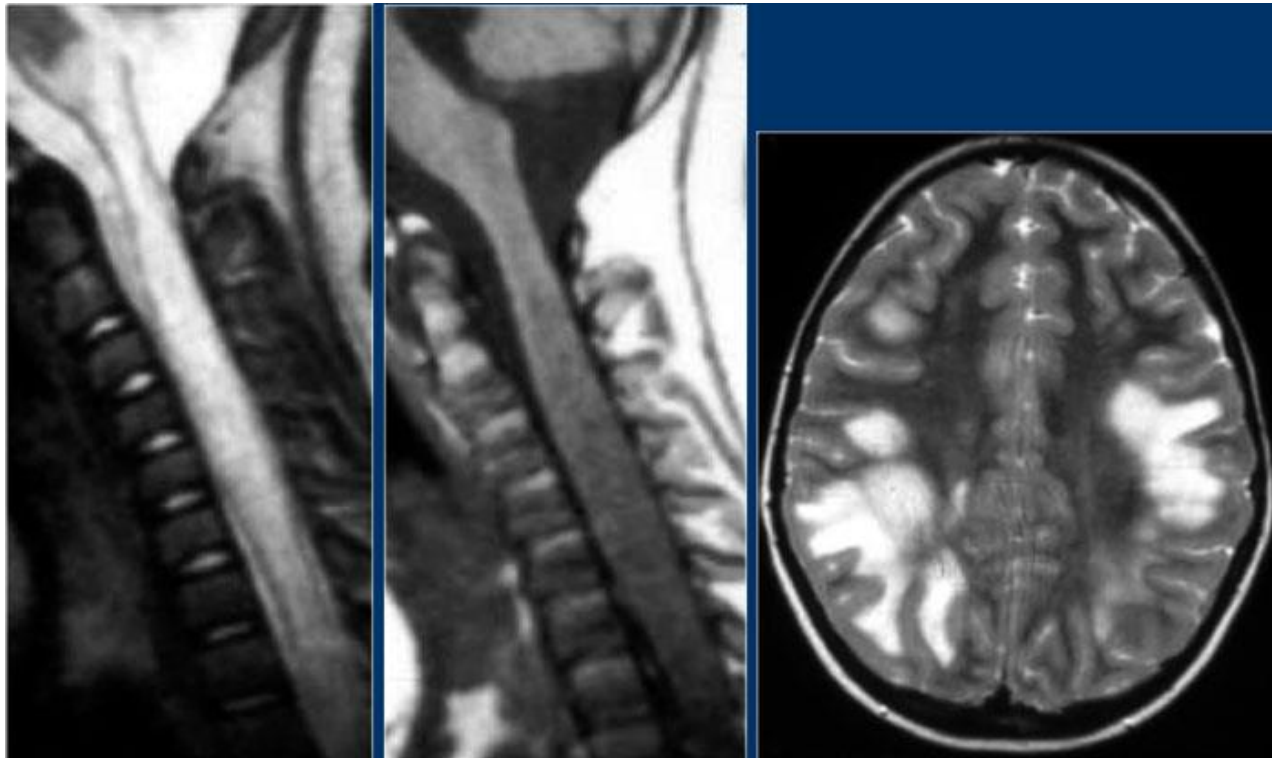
T2WI sagittal MRI of cervical spine demonstrate diffuse involvement of the spinal cord extending from C1 to C7 (between arrows) and mildly expanding the cord. The lesion is isointense on the T1WI and in T1+Gd (contrast) nonenhanced. Again there is also involvement of the brain suggesting ADEM.
